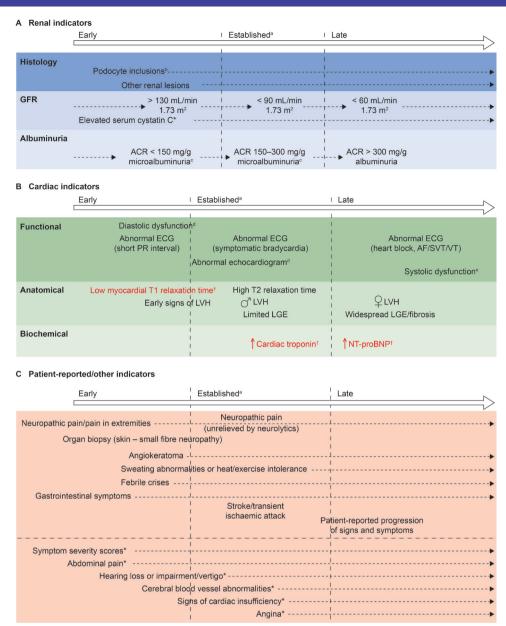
Chronology of consensus indicators. (A) \*Indicator tested for, but not achieving, consensus in round 3. (B) †Indicators in red text achieved consensus both as currently used, and suitable for future adoption, because they are not available in all centres. Two further indicators (abnormal PET/MRI and increased serum lyso Gb3) that were included in round 2 of the initiative but were not taken forward to round 3 are not shown here based on guidance from the cochairs. (C) \*Indicator tested for, but not achieving, consensus in round 3. Other indicators tested for, but not achieving, consensus, and which are not included here owing to their lack of specificity were: biomarkers; patient-reported outcomes; absenteeism owing to ill health; and palpitations. alidicators that currently would be likely to trigger FD-specific treatment initiation. In isolation, probably insufficient justification for FD-specific treatment initiation. Microalbuminuria could be a trigger for further investigation, such as confirmatory biopsy, and subsequent initiation of disease-specific treatment. Including decreased myocardial strain and strain rate, tissue Doppler abnormalities, enlarged left atrium, abnormal wall motion or pulmonary vein abnormalities. Including shortened PR interval, non-SVT and symptomatic bradycardia. ACR, albumin:creatinine ratio; AF, atrial fibrillation; FD, Fabry disease; GFR, glomerular filtration rate; LGE, late gadolinium enhancement; LVH, left ventricular hypertrophy; lyso Gb3, globotriaosylsphingosine; NT-pro-BNP, N-terminal probrain natriuretic peptide; PET, positron emission tomography; SVT, sustained VT; VT, ventricular tachycardia.
